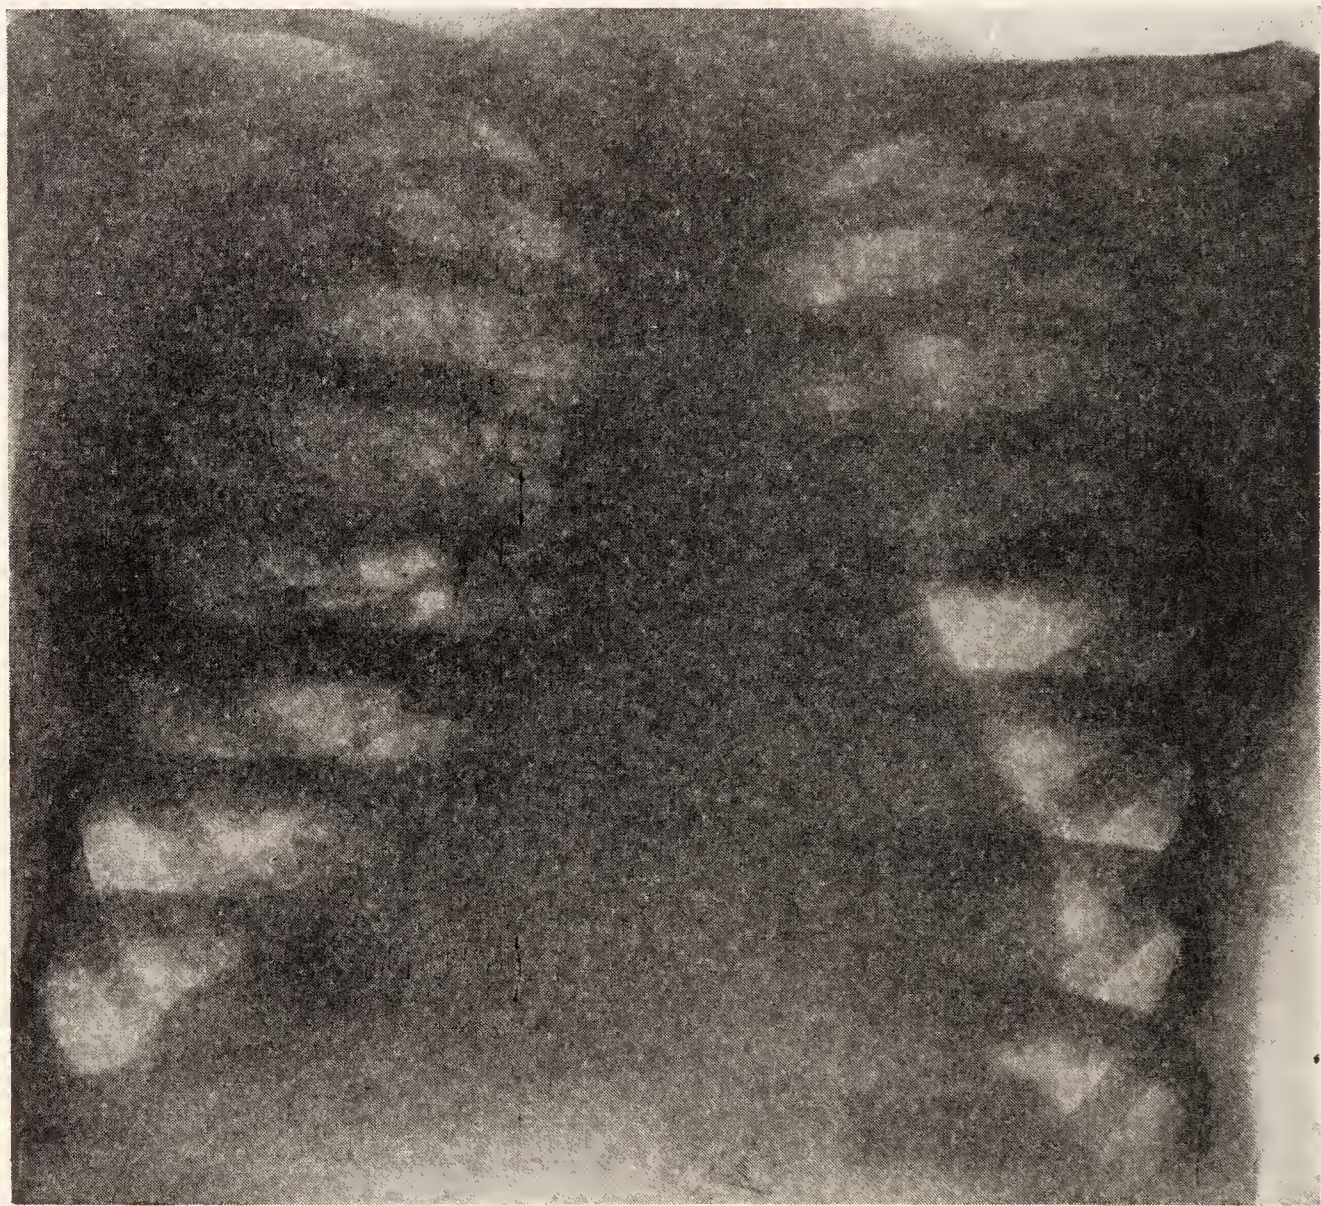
Heart symmetrically enlarged, not displaced. Seen from behind. Bronchiectasis with focal pneumonia and gangrene, especially right lung. Several areas suggest cavities. (Roentgenological Department, Massachusetts General Hospital.)
